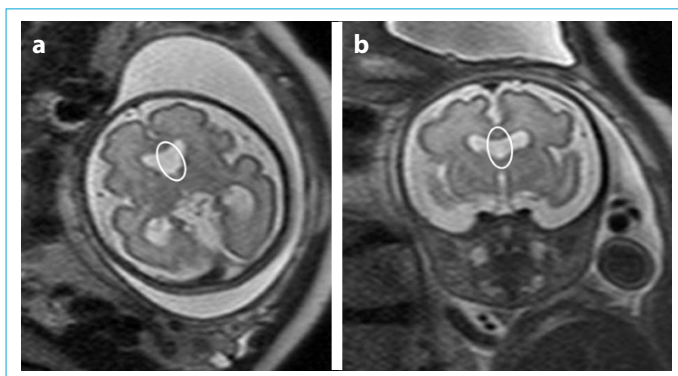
(a, b). Axial (a) and coronal (b) T2-weighted images show septum pellucidum which separates lateral ventricles is not observed (circle).
